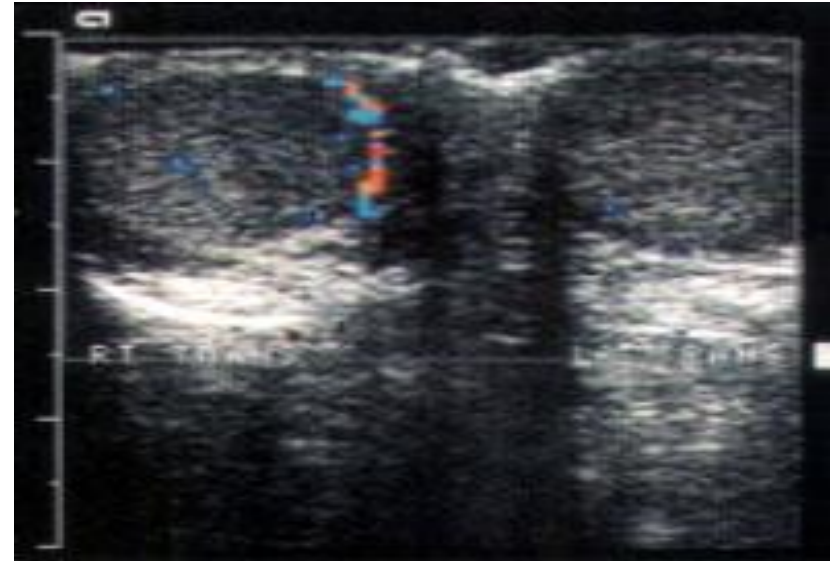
Color Doppler ultrasonogram showing acute torsion affecting the left testis in a 14-year-old boy who had acute pain for four hours. Note decreased blood flow in the left testis compared with the right testis
